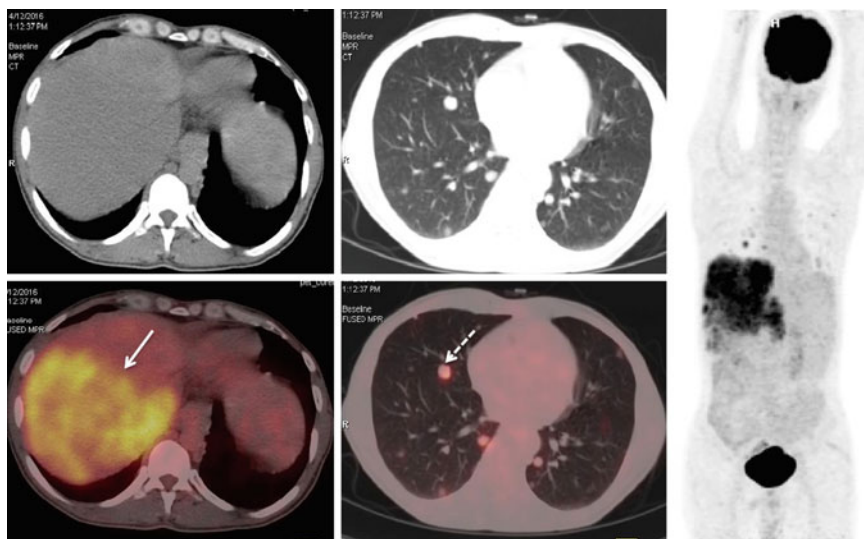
A 42-year-old man with hepatocellular carcinoma. PET/CT for staging revealed a primary tumour in the liver (*white arrow*) with bilateral lung metastases (*white dashed arrow*), thereby upstaging the disease.
